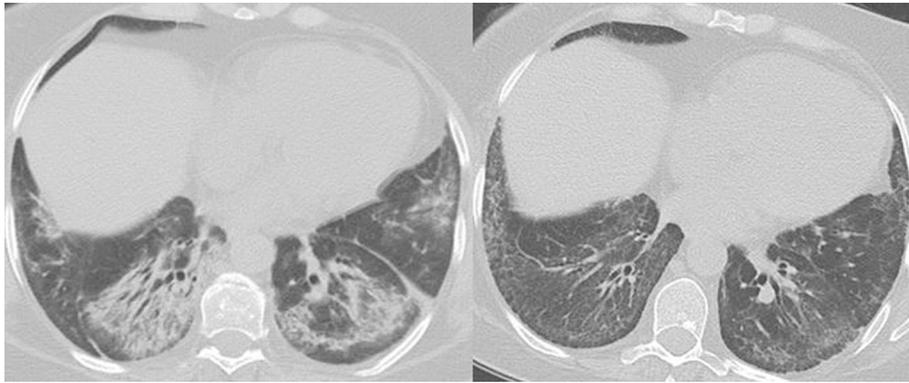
(A) Axial transverse CT image of lower lung zones in a 45-year-old woman positive for anti-PM-Scl antibody who presented with ILD is consistent with a non-specific interstitial pneumonia (NSIP) pattern, biopsy proven a year prior to the development of myositis, Raynaud's phenomenon and sclerodactyly. (B) Same patient 2 years later after rituximab infusion.
